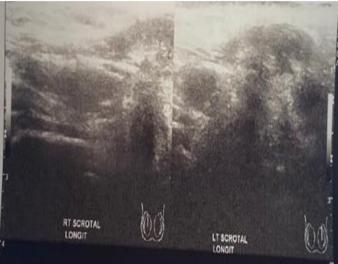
Uro genital ultrasound october 2021
